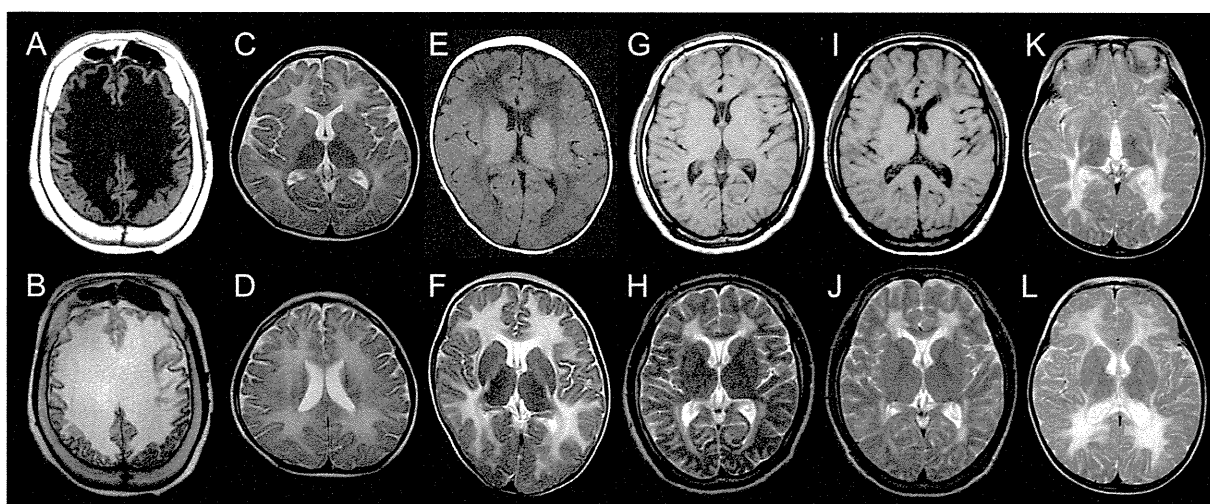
Brain MRI findings of the patients examined. Axial images show various degrees of abnormal white matter. (A and B) Patient 1 examined at 60 years of age. (C and D) Patient 2 examined at 3 years of age. (E and F) Patient 3 examined at 8 months of age. (G and H) Patient 4 examined at 13 years of age. (I and J) Patient 5 examined at 16 years of age. (K and L) Patient 6 examined at 13 months of age. T1-weighted axial images (A, E, G, and I) and T2-weighted axial images (B–D, F, H, and J–L). Periventricular zones of patient 1 are not distinguished (A and B). T2-high intensity is only shown in deep white matter, indicating early disease stage in patient 4 and 5 (H and J, respectively).
